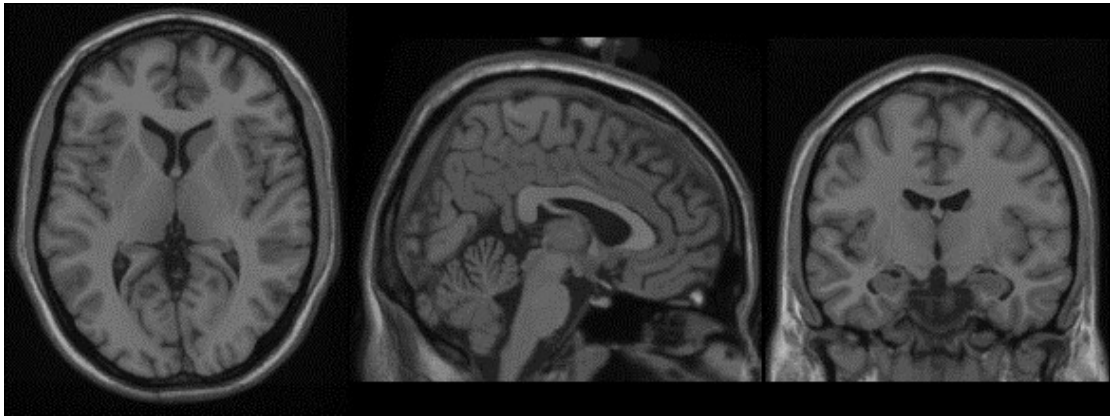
intensity-averaged MRI scans of the Colin27 atlas [153].
